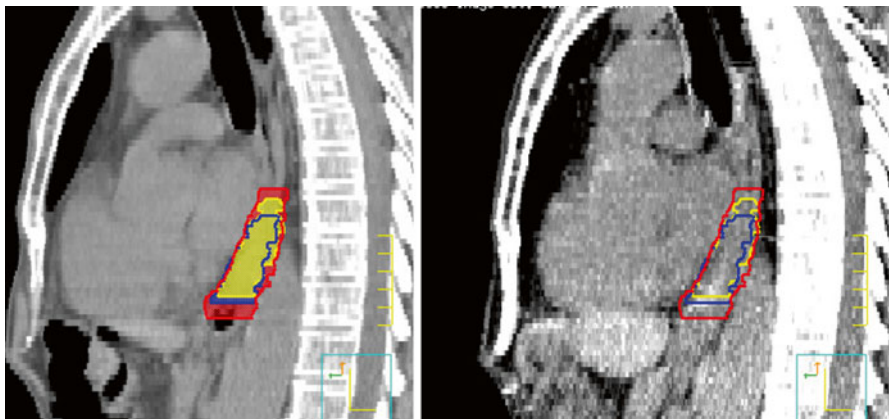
4D-CT estimates internal motion in all extents, especially for the superior-inferior and anteroposterior motion of a distal esophageal tumor. *Blue* contours, conventional CT; *yellow* contours, PET-CT fusion; *red* contours, 4D-CT MIP-based delineation
